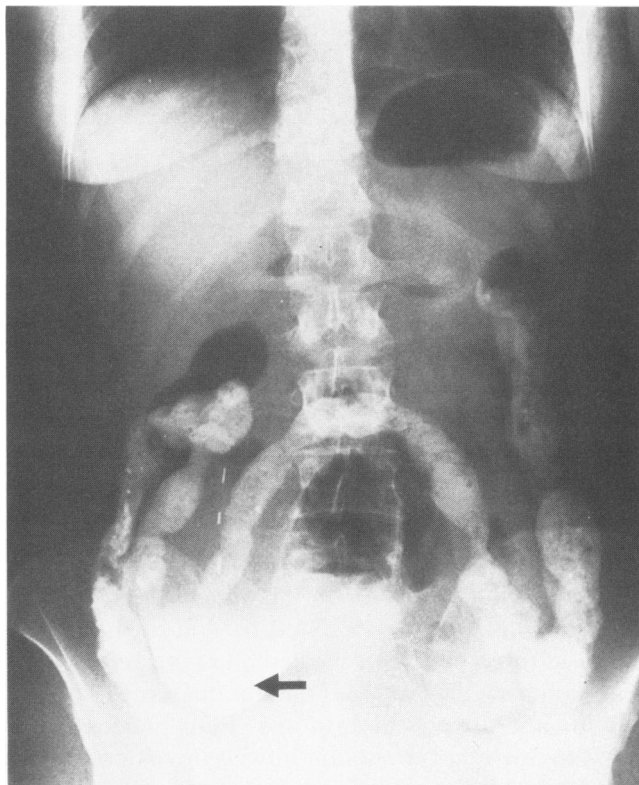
A plain abdominal x-ray taken 14 days after a contrast upper gastrointestinal roentgenogram. There was still some barium in the dilated duodenum (arrow) and colon (Case 11).
